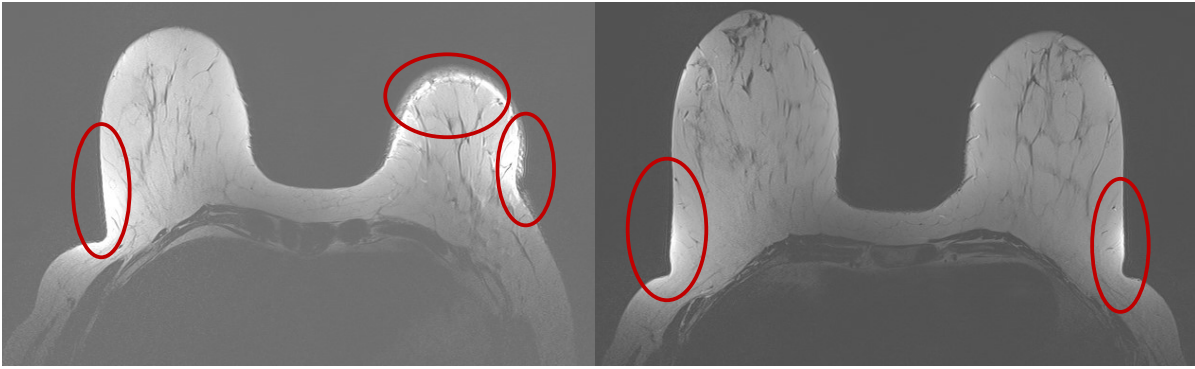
Examples of the two categories of MRI artifacts that are available in datasets from the Medical University of Vienna. The first image is from signal processing artifacts, which have a partial volume (left). The second image is from hardware-related artifacts, which is inhomogeneity (right). Red circles emphasize those two problems.
